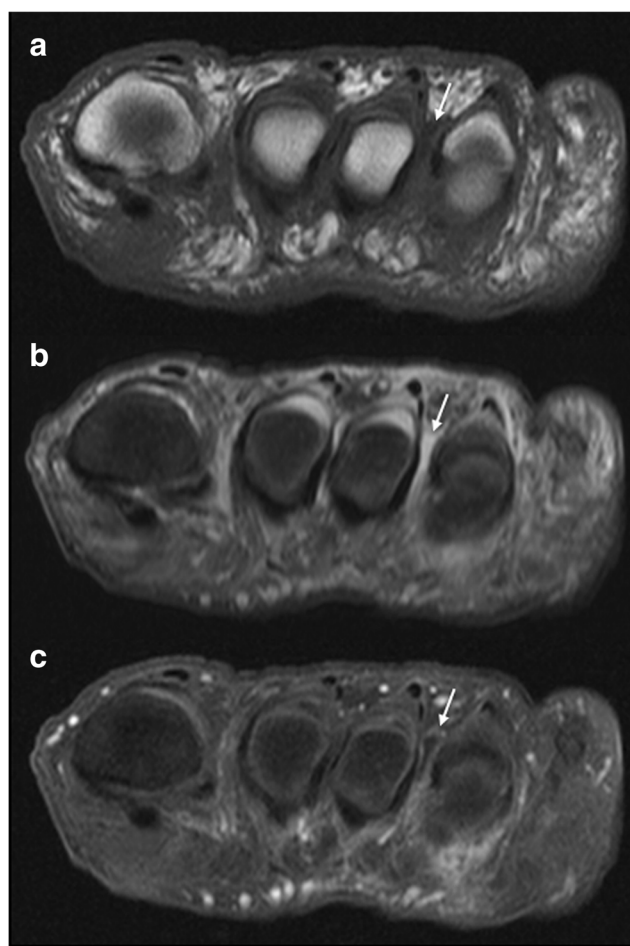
Coronal axis of the right foot of a 48-year-old woman with forefoot pain. a The image is T1-weighted, b the image is fat-suppressed PD, and c the image is contrast-enhanced fat-suppressed T1-weighted. *White arrows* indicate evidence of third intermetatarsal bursitis with a hypointense signal (a), a hyperintense signal (b), and peripheral enhancement of the bursal wall (c)
